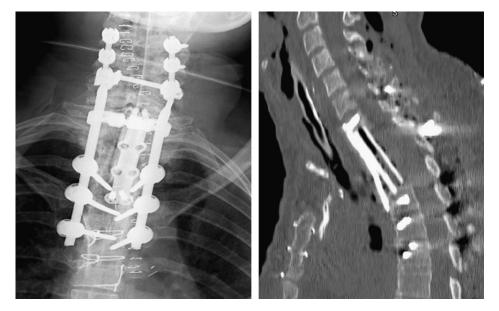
Postoperative plain film and CT scan of a patient who underwent combined anterior-posterior resection and fusion of a GCT at the cervical-thoracic junction.
